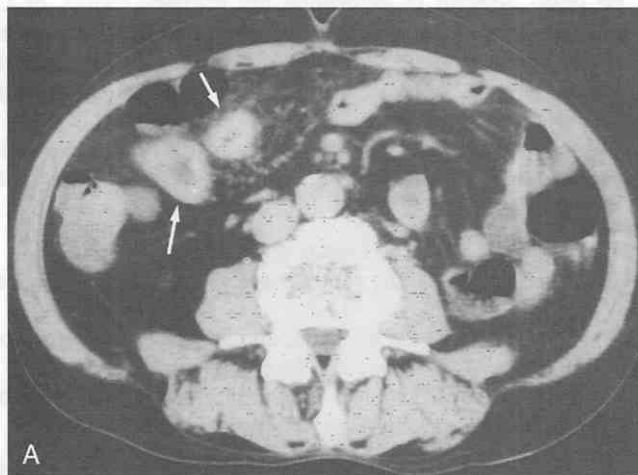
Intestinal ischemia due to mesenteric arterial occlusion. *A*, CT scan shows nonspecific bowel wall thickening (arrows) of the ileum with prominent mesenteric vessels in the regional mesentery. Thromboembolism is not definitively demonstrated. *B*, Arterial phase of the superior mesenteric artery (SMA) angiogram shows occlusion (arrow) of the ileocolic branch of the SMA. *C*, Venous phase of the SMA angiogram shows delayed pooling (arrows) of contrast material in the ischemic ileal segment. (From Ha HK: CT in the early detection of strangulation in intestinal obstruction. *Semin Ultrasound CT MRI* 16:141-150, 1995.)
